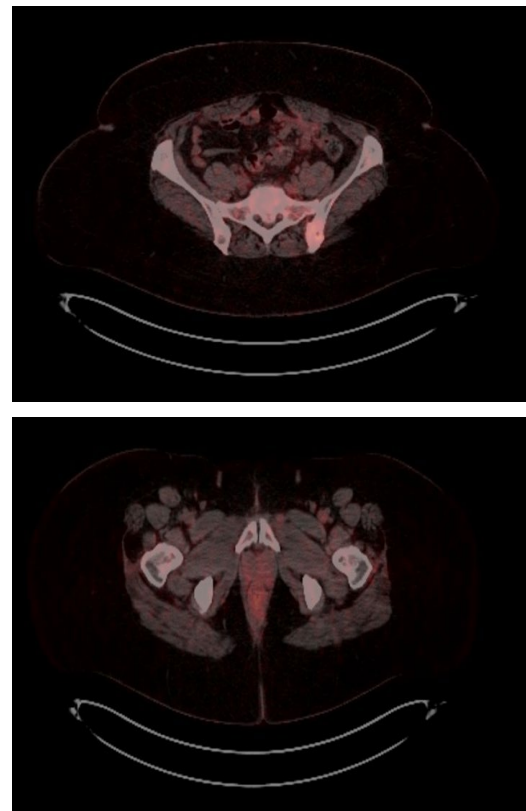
PET scan showing decreased FDG uptake with increased sclerotic in pelvic bones, indicating treatment response, February 2025.
